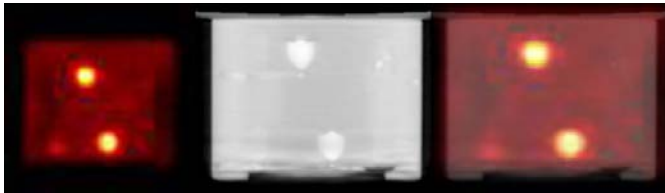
Transverse sliced images of the SPECT (VAOR trajectory) (left), CT (middle) and fused data (right) showing good agreement.
